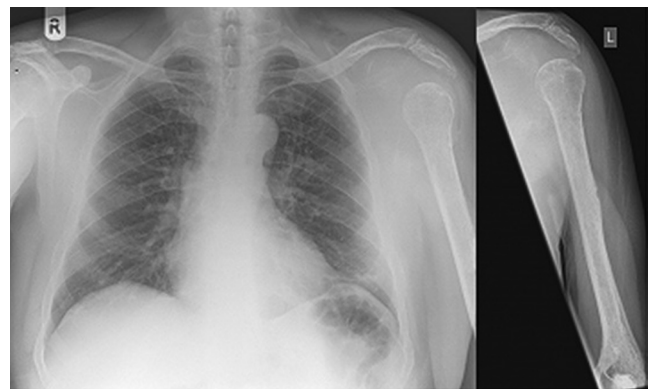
59-year-old male with myeloma. Plain films of the chest and left humerus. The left scapula is almost entirely destroyed. Only a small amount of the acromion remains. The film of the left humerus demonstrates permeative bone loss throughout. A well-defined, punched-out lytic lesion is seen in relation to the midshaft of the left humerus.
